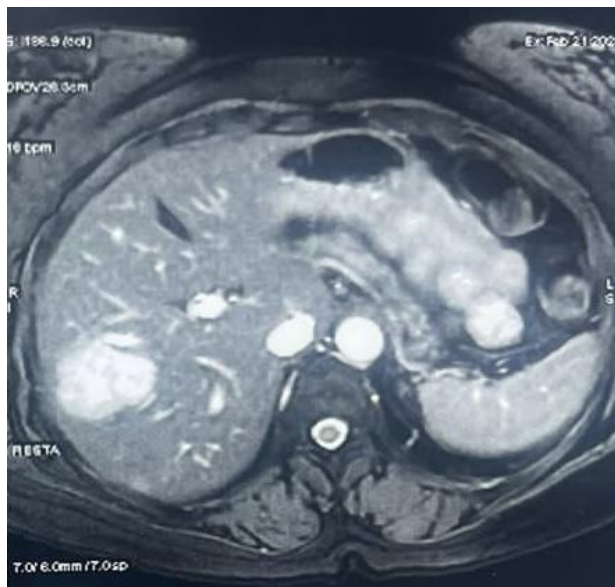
liver MRI showing a nodular lesion with T2 hyper signal and peripheral enhancement
